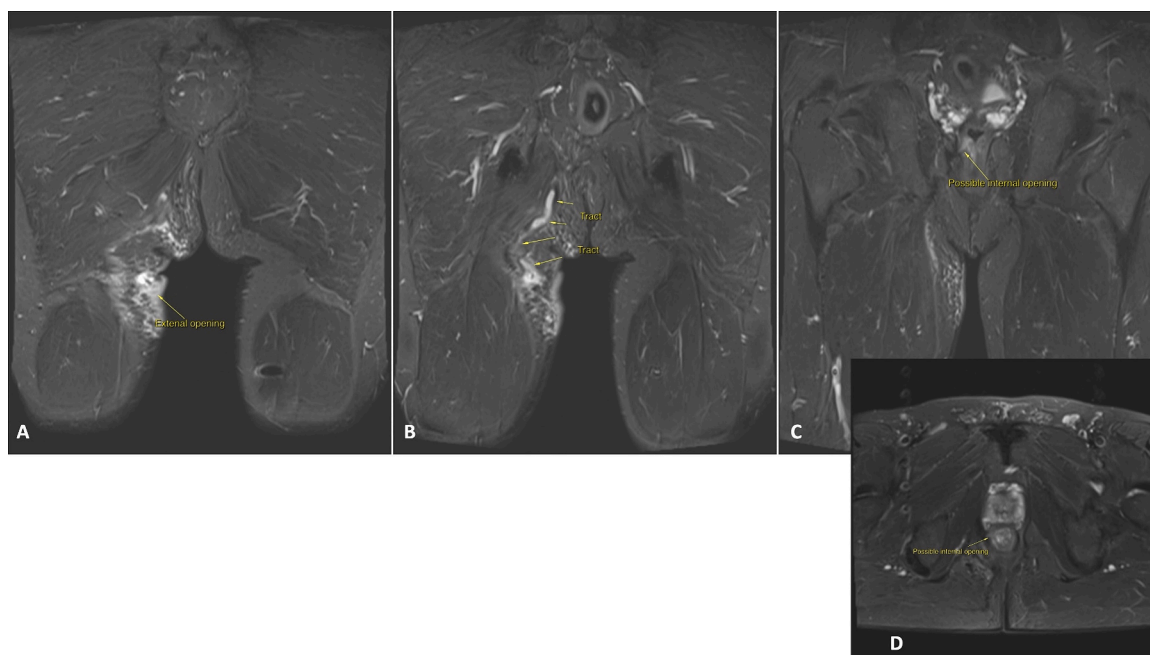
MRI pelvis findings (25/08/2021).
